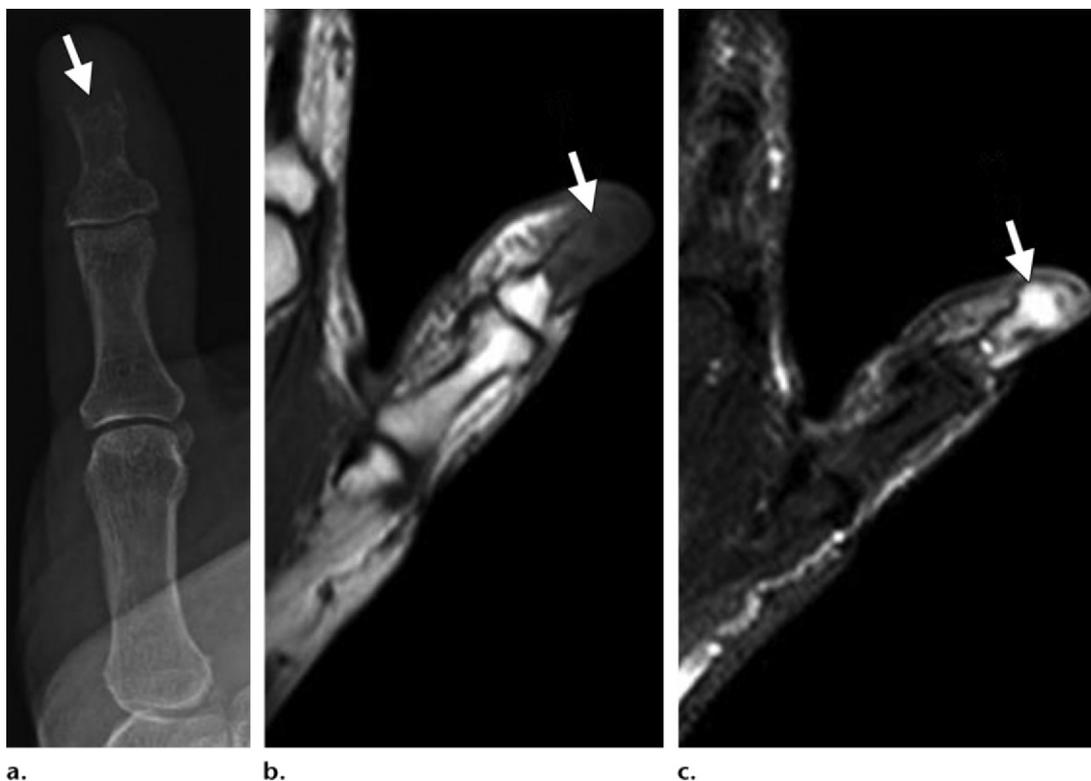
Giant cell tumor of the bone in a 54-year-old woman with a history of renal cell carcinoma and a 1-month history of swelling of the tuft of the first digit. (a) Frontal radiograph demonstrates aggressive-appearing lytic destruction of the tuft of the first digit (arrow). (b, c) Corresponding coronal T1-weighted (b) and fat-saturated T2-weighted (c) MR images demonstrate a destructive T1-hypointense and T2-hyperintense lesion (arrow). Imaging findings raised concern for possible metastatic disease from primary renal cell carcinoma, or perhaps infection. Pathologic analysis revealed a giant cell tumor of the bone.
